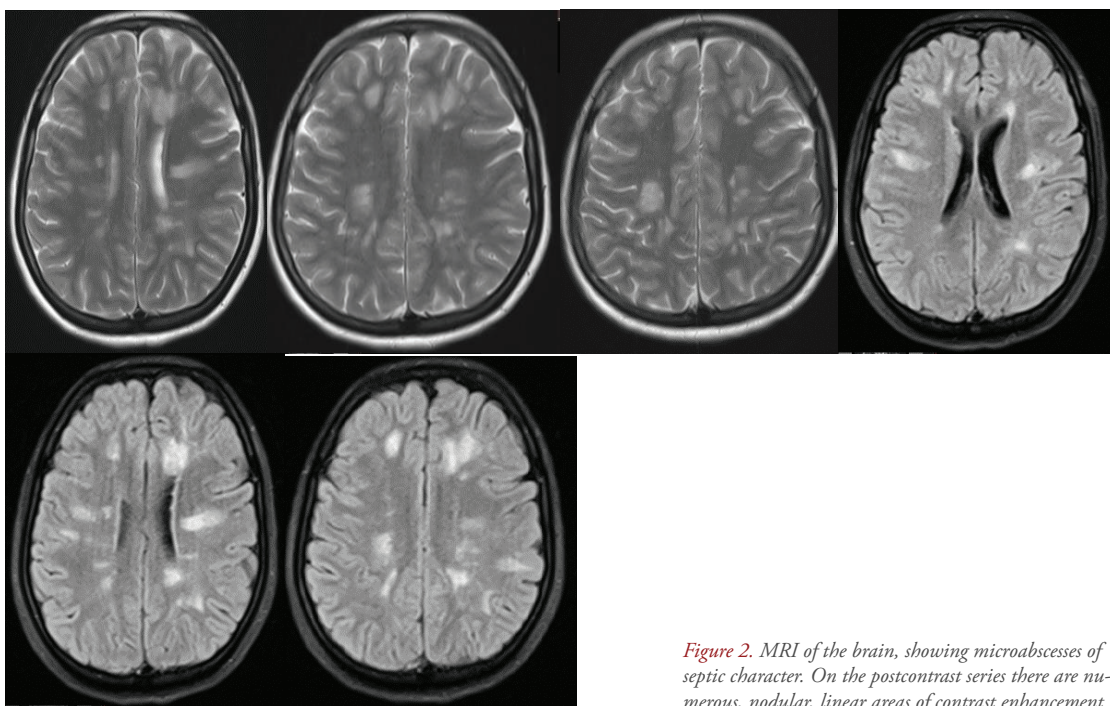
MRI of the brain, showing microabscesses of septic character. On the postcontrast series there are numerous, nodular, linear areas of contrast enhancement.
